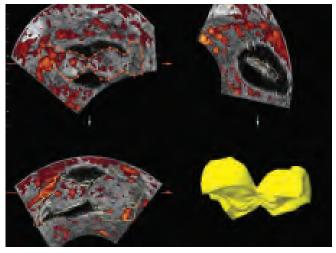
Two endometrial polyps in SIS 3D multiplanar acquisition with power Doppler and inversion mode
